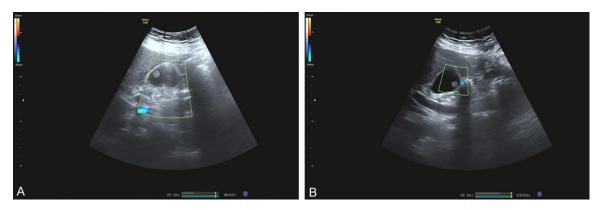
Blood flow characteristics of cholesterol polyps diagnosed by ultrasound. Hyperechoic mass with clear outline and no blood flow signal in the posterior wall of the gallbladder (A). Hyperechoic lesion with mulberry-like attachment to the posterior wall of the gallbladder and inconspicuous blood flow signal (B).
